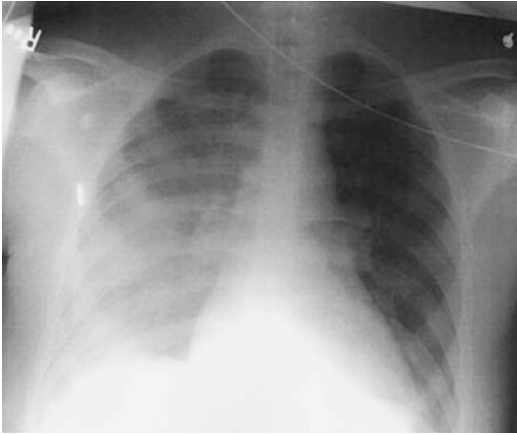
Anteroposterior chest x-ray of a 33-year-old man with known MG for 1 year, who presented with worsening of generalized weakness, and dysphagia, followed by tachypnea and fever. The x-ray on admission revealed right lower lung pneumonia and left lower lobe atelectasis. The patient required mechanical ventilation within 12 h of admission
